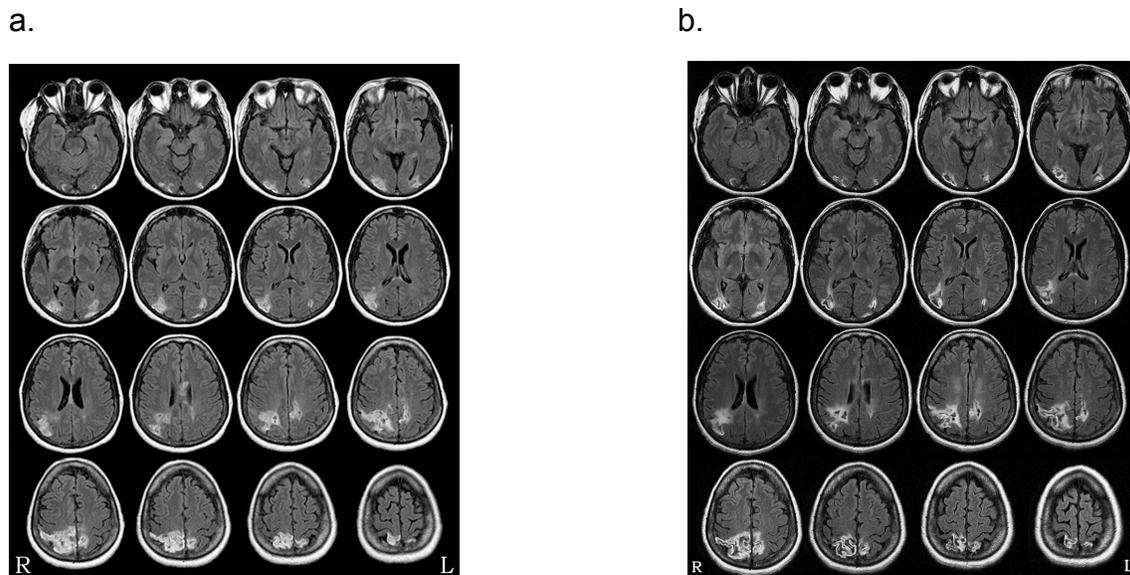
MRI scans of patient SL at (a) Time 1 and (b) Time 2
